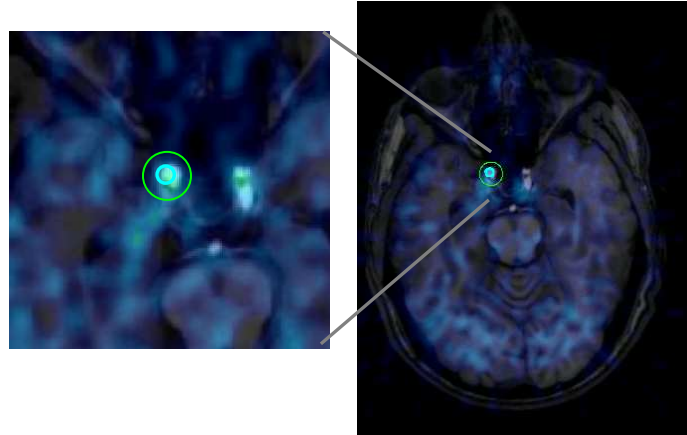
Region of interest on the co-registered PET-MRI image. The smaller ROI is used to estimate the arterial activity, and the bigger ROI is for tissue spillover estimation.
